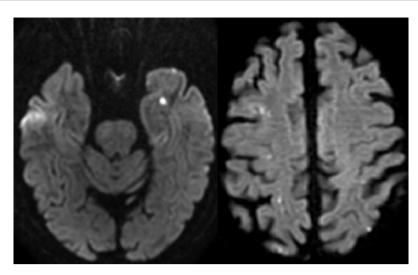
Brain MRI of 24/06/2019, DWI sequence and axial sections: bilateral ischemic stroke recurrence of mainly junctional topography.
